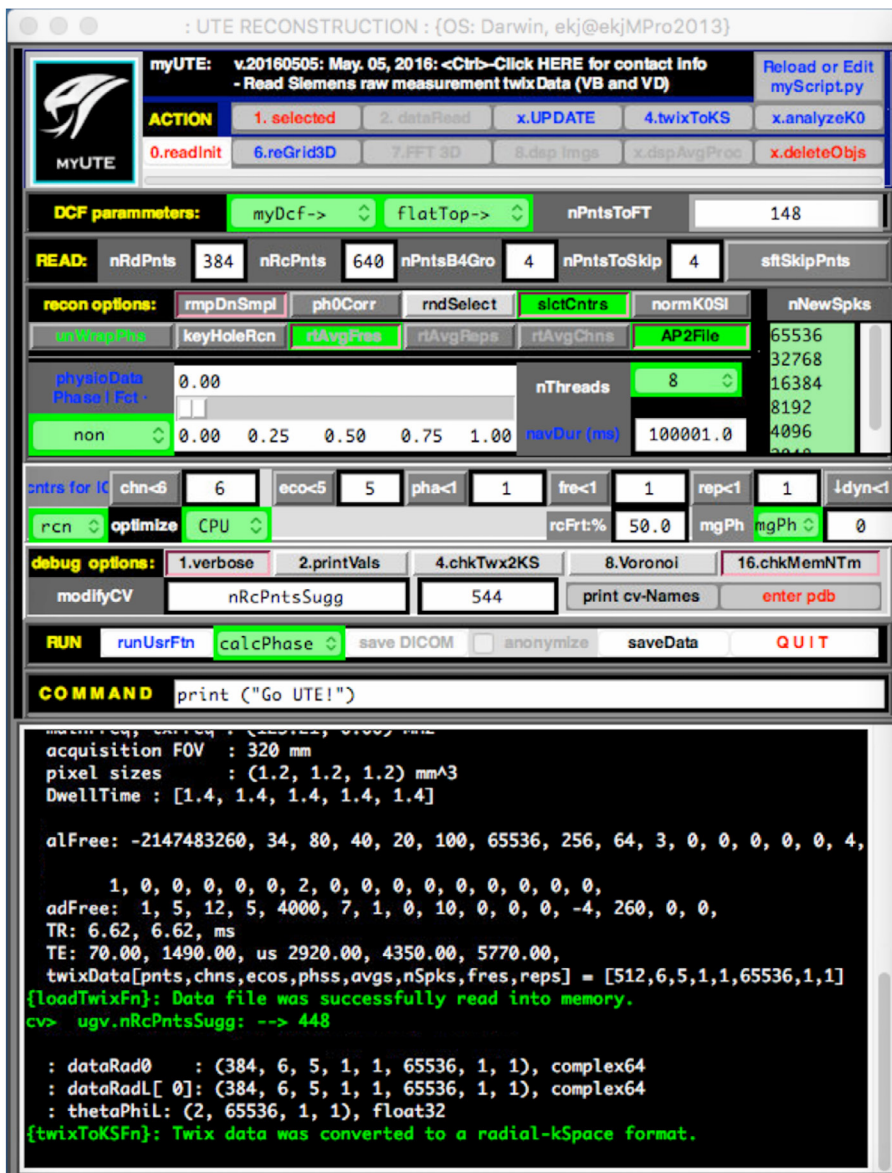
Front-end of GUI-based reconstruction software. The software is very flexible to set the reconstruction as well as the acquisition parameters. It can selectively reconstruct specific loop counters, such as receive channels, echoes, and repetitions. The current software is capable to reconstruct the UTE raw data from Siemens MRI system with VB and VD version.
